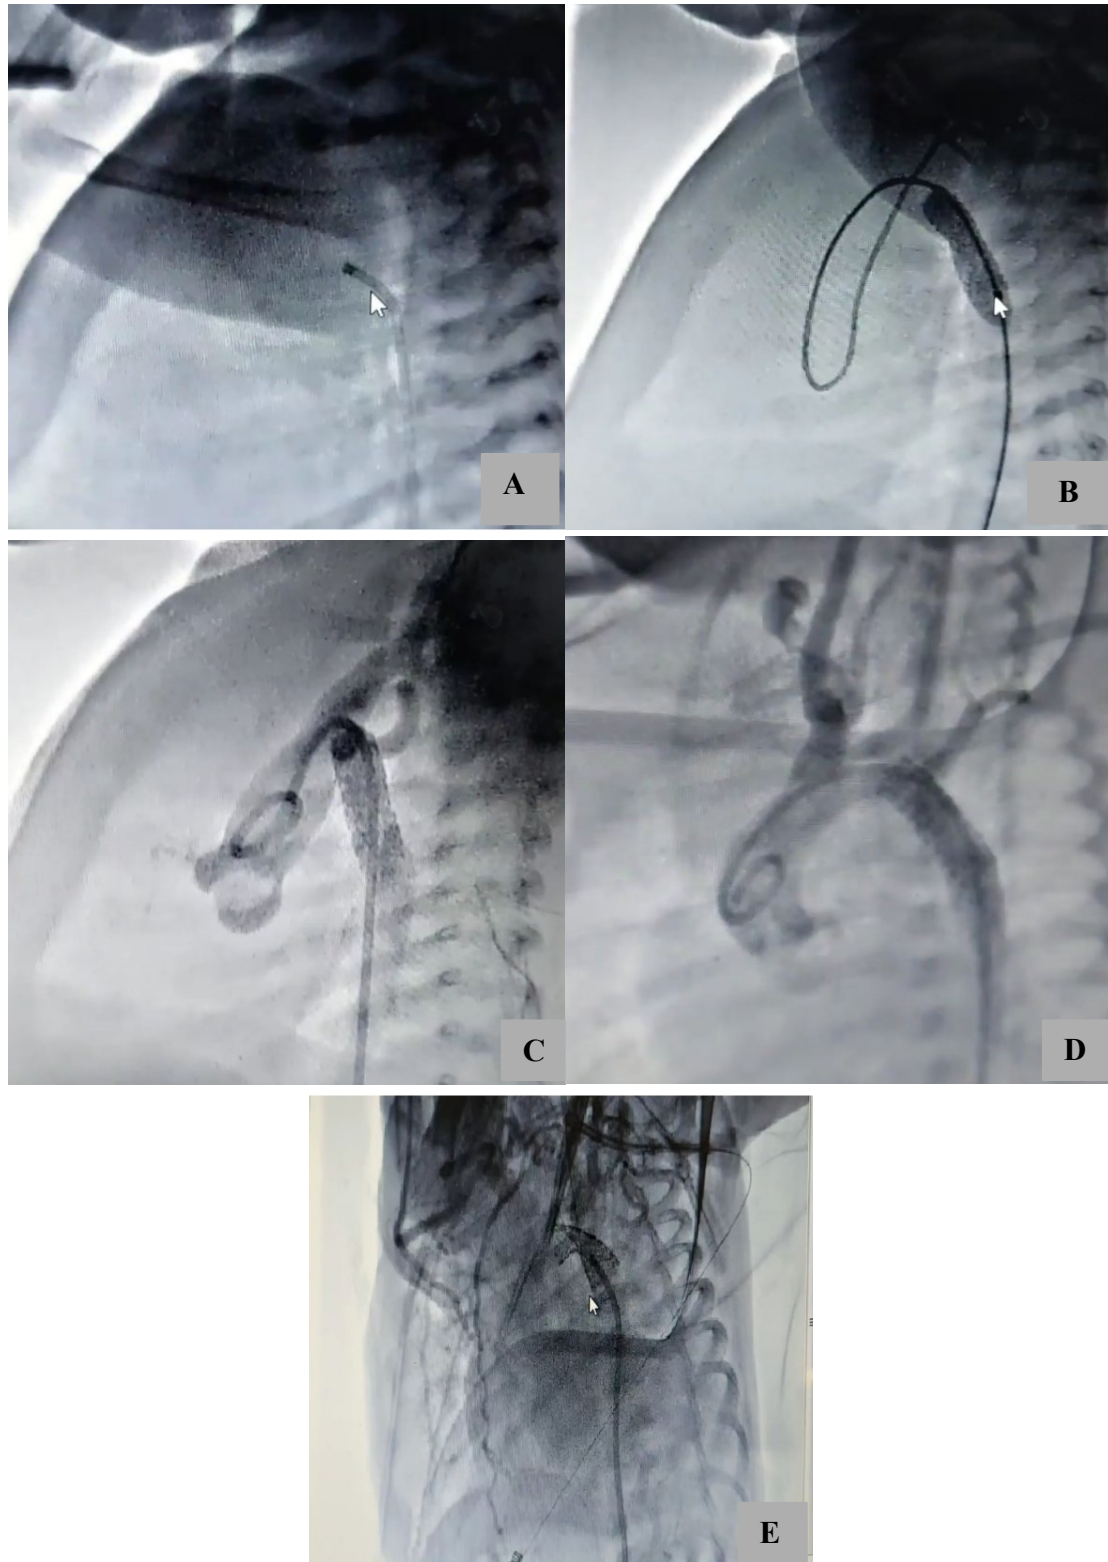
Procedural images of a 28-day-old infant with coarctation of the aorta (CoA) and severe heart failure. (A) Pre-procedural echocardiography showed a discrete CoA with a pressure gradient of 50 mmHg and impaired left ventricular function. (B) Intra-procedural fluoroscopy demonstrated vascular access and balloon preparation. (C) Deployment of a stent using a balloon-expandable technique. (D)&(E) Post-procedural angiography (stent patency with residual gradient < 10mmHg). This case highlights the efficacy of stenting in managing severe CoA with heart failure in an infant
